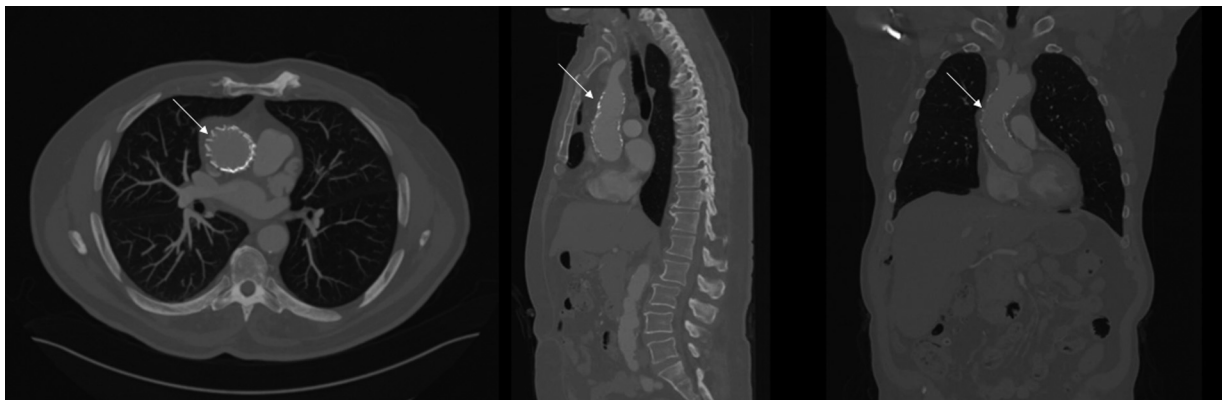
Computed tomography angiography 1 month postoperatively: appropriate graft placement (arrows) without evidence of leak.
